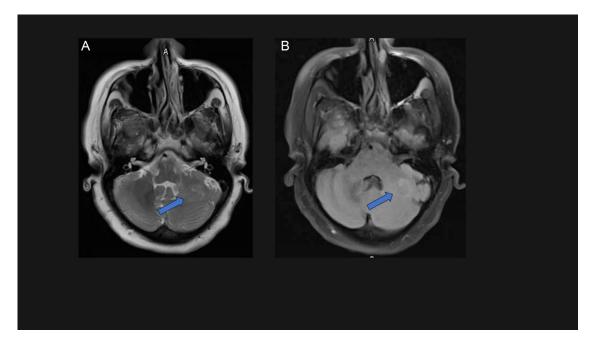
(A) and (B) Axial T2 and FLAIR images showing left cerebellar hemisphere pseudomass T2 heterogenous with iso/hyperintense signal with mild distortion of adjacent folia and no mass effect.
